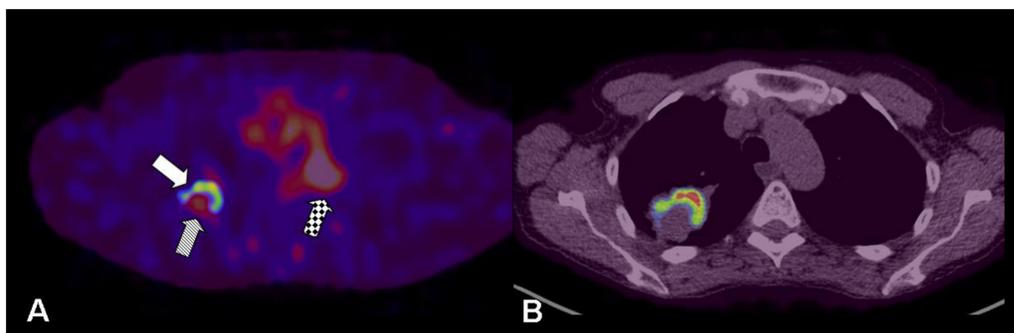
Fused image of SAP-scan (striped arrow specific amyloid binding; checked arrow bloodpool) and FDG-PET (white arrow) show central SAP-accumulation with no FDG-uptake within the center of the tumour. (A) Fused image of FDG-PET with CT-scan (B).
